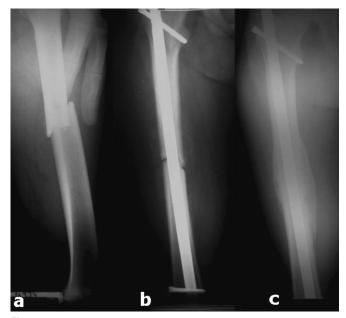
(A–C). *Healing progression of a transverse midshaft fracture in a 14 year old patient. Radiographs at presentation* (A), *1* (B), *and 13 months after nailing* (C).
